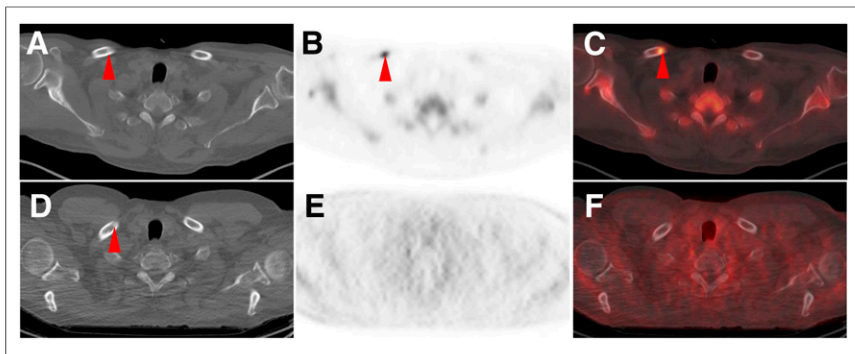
CT (A), Na¹⁸F PET (B), Na¹⁸F PET/CT (C) and, at same level, CT (D), ¹⁸F-DCFPyL PET (E), and ¹⁸F-DCFPyL PET/CT (F) axial images of patient with widely metastatic PCa. Both modalities show subtle sclerotic lesion in right clavicle (arrowheads), but only Na¹⁸F shows associated intense uptake compatible with site of PCa. Most lesions with Na¹⁸F uptake that lacked ¹⁸F-DCFPyL uptake were sclerotic.
